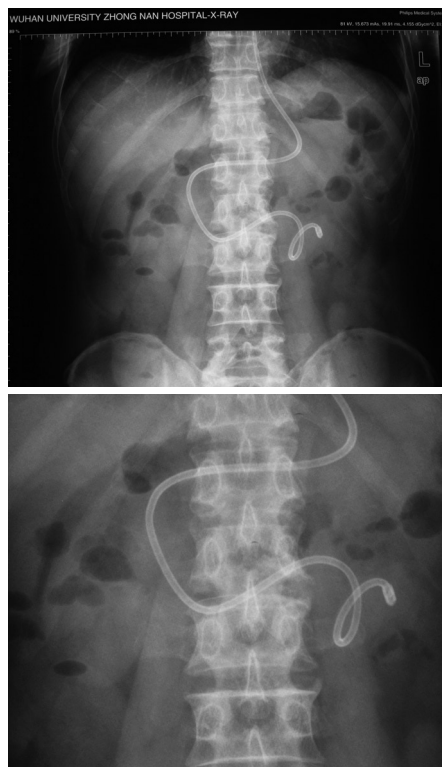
Placement of a spiral nasojejunal feeding tube in the intestine below Treitz ligament, 48 h after X-ray examination.
